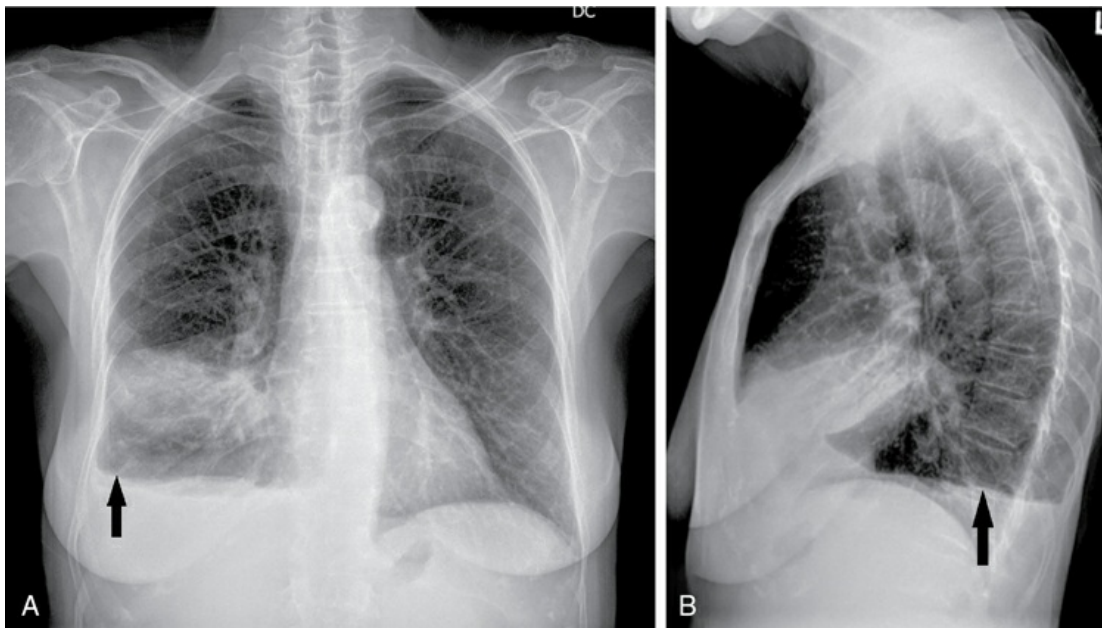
Posteroanterior (A) and lateral (B) chest radiographs showing a lobar pneumonia in the right middle lobe with an associated pleural effusion. Arrows point to the top level of the pleural effusion. *Source:* (Courtesy of Dr. Laura Avery.)
